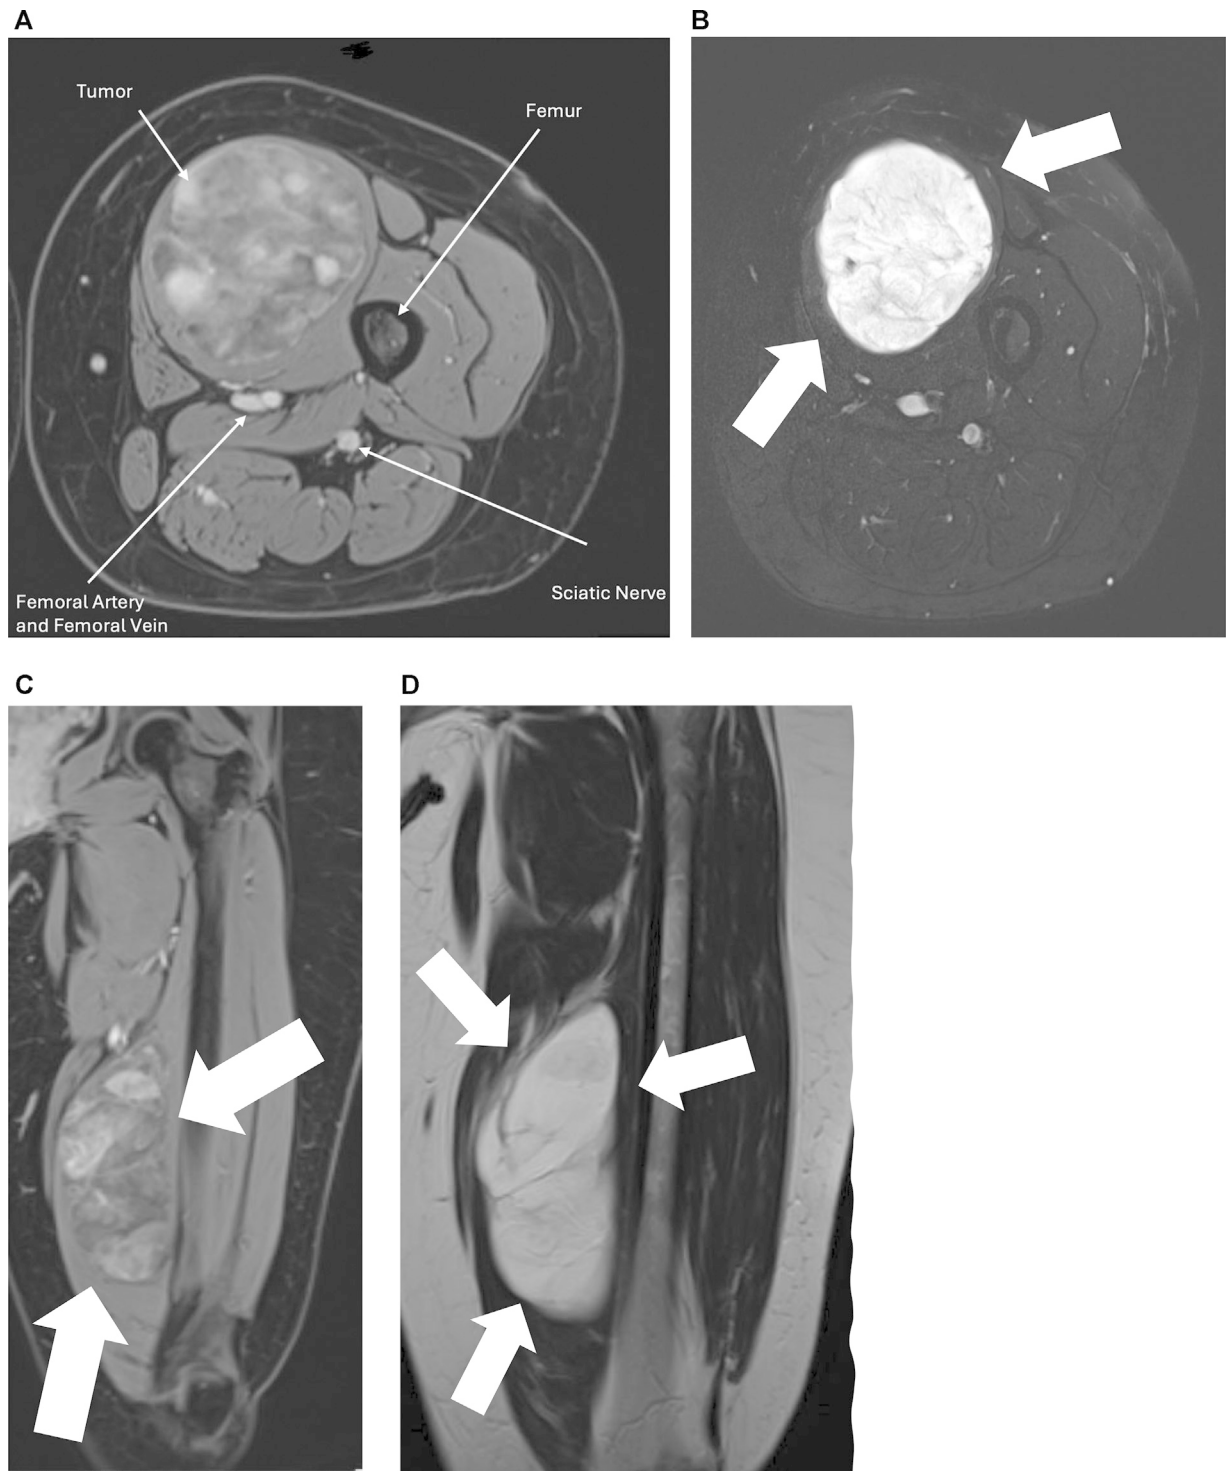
Magnetic resonance imaging of the left thigh at mid-thigh level. (A) Axial T1-weighted MR image with gadolinium (postcontrast), labeled to show the tumor, femur, femoral vessels, and sciatic nerve. (B) Axial T2-weighted MR image of the thigh. (C) Sagittal T1-weighted MR image with gadolinium (postcontrast). (D) Sagittal T2-weighted MR image. The intramuscular mass (white arrows) in the vastus medialis measures approximately 7.3 × 6.9 × 14.4 cm and contains internal septations. It exhibits heterogeneous signal intensities—predominantly hypointense on T1WI, hyperintense on T2WI with incomplete fat suppression on Short Tau Inversion Recovery (STIR)—and shows irregular enhancement on the postcontrast images. No blooming artifact is present on gradient-echo sequences (GRE). The tumor does not invade the subcutaneous tissue, and the surrounding muscles and adjacent femur appear normal. No abnormal signal intensities within the left vastus medialis muscle (surrounding this mass).
